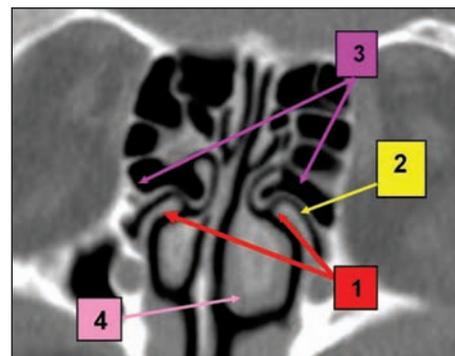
Paranasal sinuses CT scan, bone window, coronal slice: 1. bilateral curved uncinatoprocess, medialized, inserted superior into the ethmoid bulla; 2. left narrowed uncinatoprocess; 3. hypertrophic, deformed ethmoid bulla; 4. important hypertrophy of the left middle turbinate
